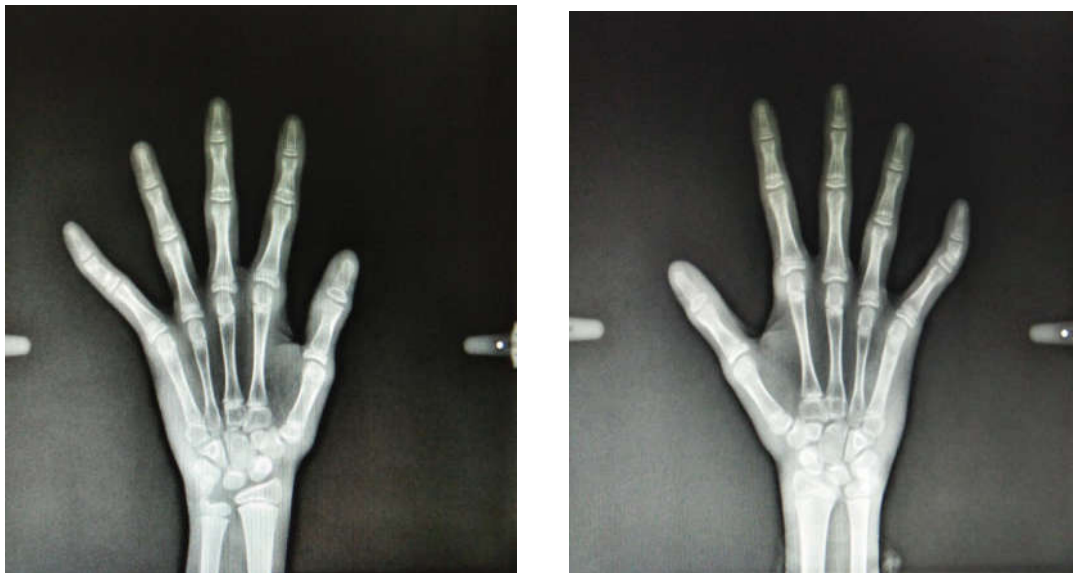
Hand wrist radiographs
